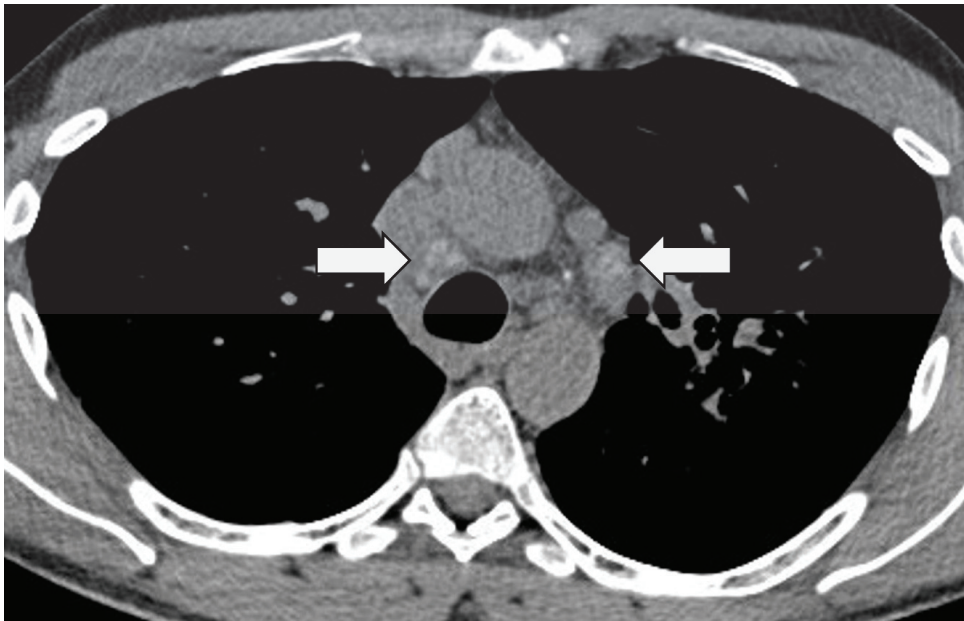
Axial CT in a patient with sarcoidosis. Images at a level below the aortic arch demonstrating classical ‘icing sugar’ calcification in mediastinal lymph nodes (arrows).
